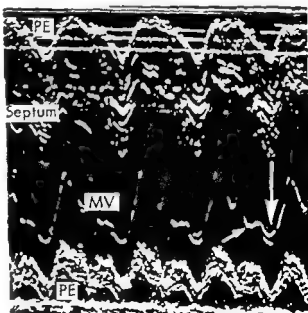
Echocardiogram of the "pseudoprolapse" of the mitral valve. PE, pericardial effusion; MV, Mitral valve. The large arrow indicates the abnormal systolic motion of the valve. The small arrow points to the "C" point. Note the congruous motion of the anterior right ventricular wall, interventricular septum, and posterior wall which is posterior at late systole.
